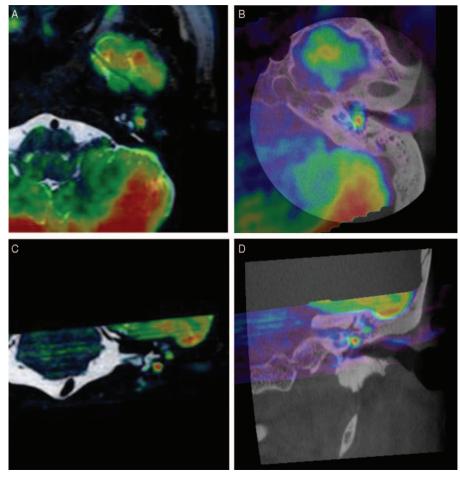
A, CMFI (axial section), B, CMDWI-CT (axial section), C, CMFI (coronal section), and D, CMDWI-CT (coronal section) of a cholesteatoma for the same patient. The CMDWI-CT shows that the cholesteatoma is located around the stapes much more clearly than the CMFI.
